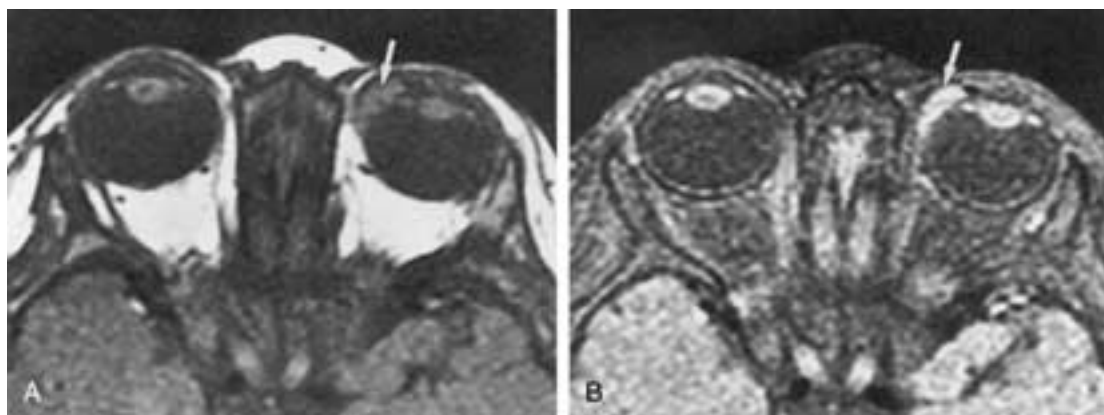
Juvenile xanthogranuloma. Precontrast axial T1-weighted (500/23, TR/TE) (A) and postcontrast T1-weighted (533/23, TR/TE) (B) MR images show an infiltrative enhancing mass involving the left eye (arrow). (Courtesy of A. Hidayat, MD, Washington, DC.)
